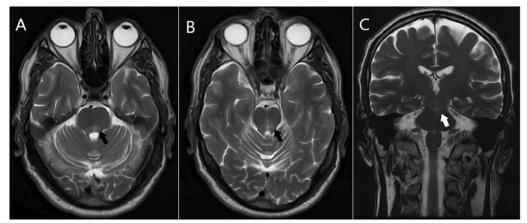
Axial and coronal turbo spin echo T2-weighted magnetic resonance imaging sequences. A Partial resolution of the hyperintense lesion in the posterior portion of the pons (black arrow). B Persistent but reduced hyperintensity in the midbrain tegmentum (black arrow). C Coronal view showing decreased signal intensity in the midbrain compared to initial study (white arrow)
